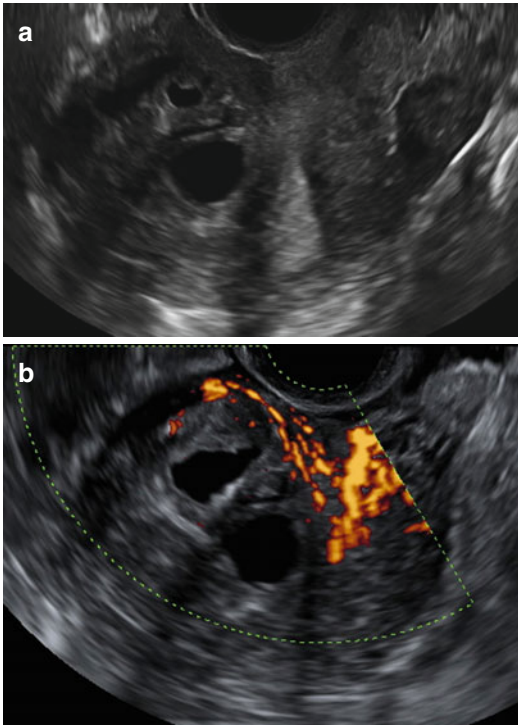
Ultrasound images of a uterus with an anterior cystic adenomyoma. Gray scale image showing inhomogeneous, irregular myometrial echotexture with cystic areas (a). Power Doppler image showing more circular vessels in the hypertrophic myometrium surrounding the cystic areas (b)
